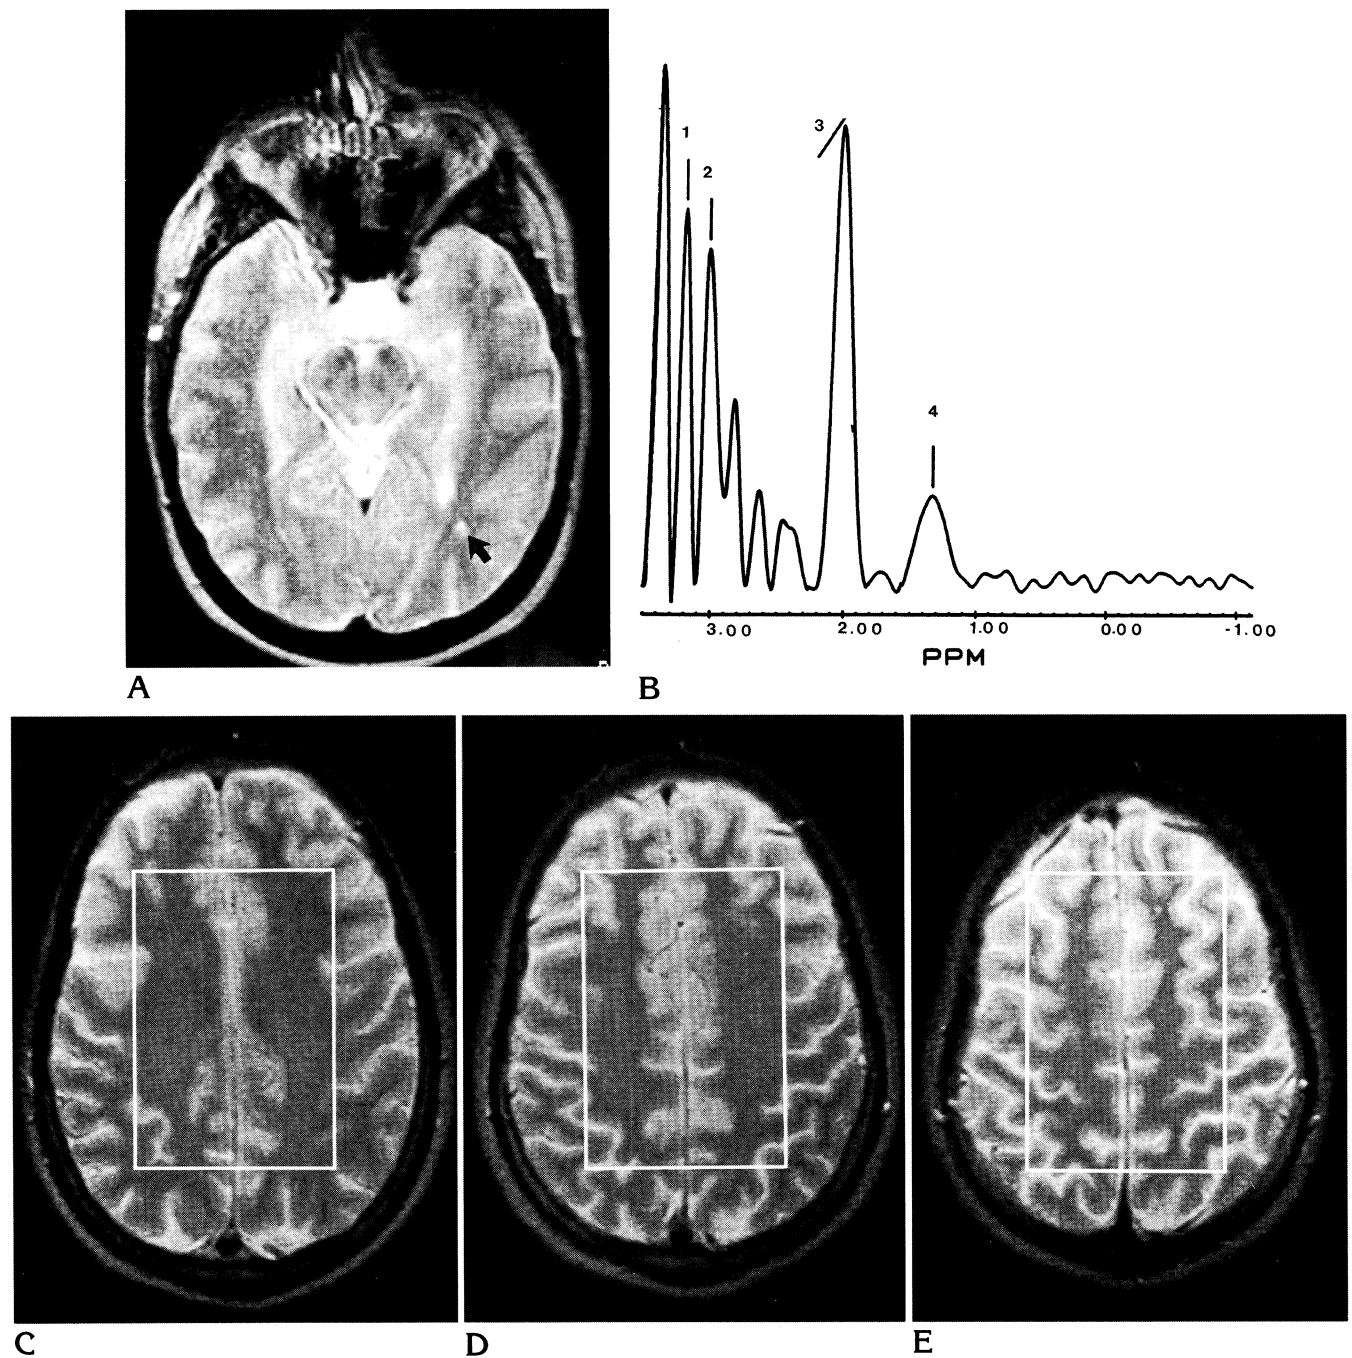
Case 7. A, MR axial T2-weighted image (3000/90/1) shows an incidental tiny left occipital signal intensity abnormality (arrow).
